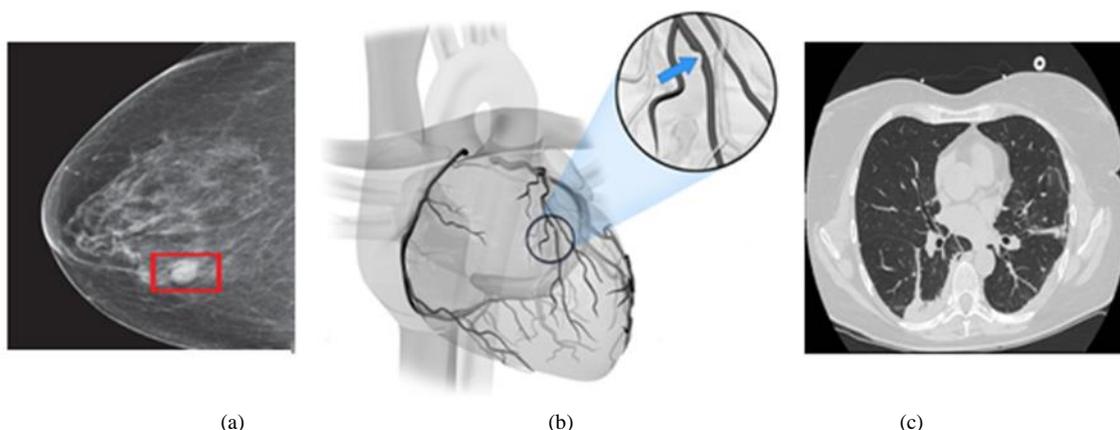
Images obtained via Mammography (a)[x], Fluoroscopy (b) & Computed Tomography (c)
